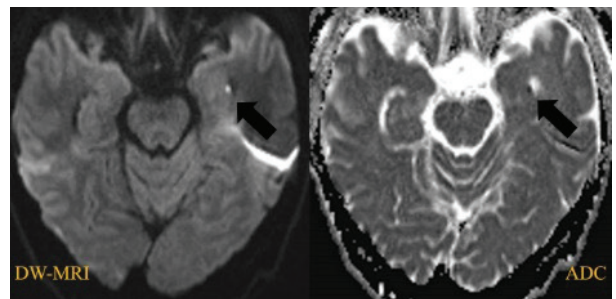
There is hippocampal restricted diffusion in the left hippocampus on DW-MRI and hypointensity is seen in the same area on the ADC map (arrows)
